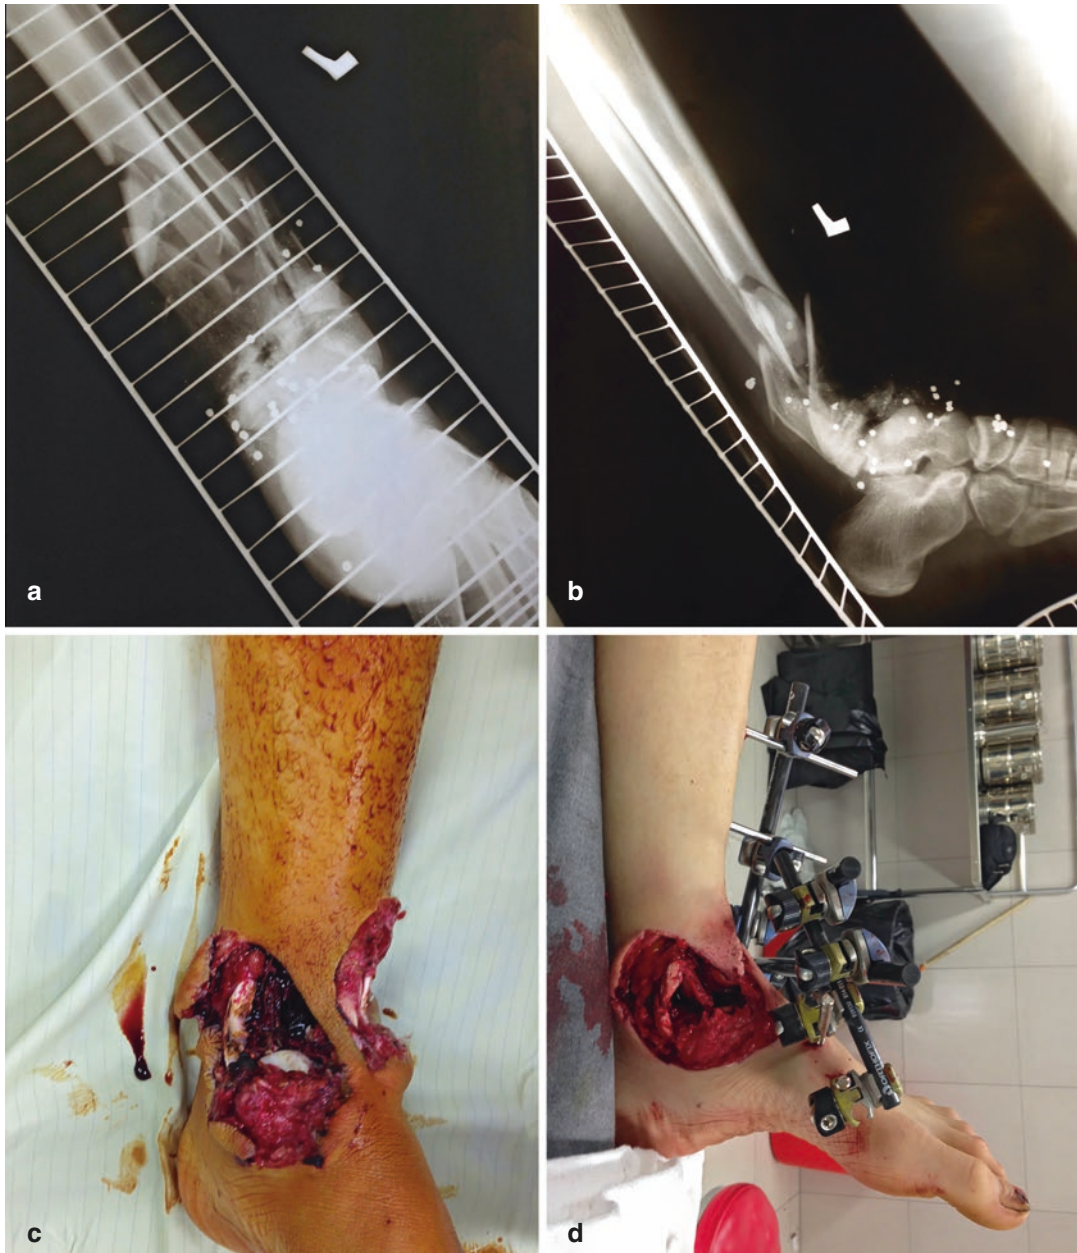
(a, b) Initial x-rays of a 14-year-old male with hunting gun injury. Distal tibia and proximal talus and parts of fibula gone with medial and lateral soft tissue loss. (c) Appearance in OR 4 days after initial debridement, showing narrow full-thickness anterior bridge of soft tissue with extensive medial defect. (d) Ex fix applied laterally to not interfere with future medial flap. No
